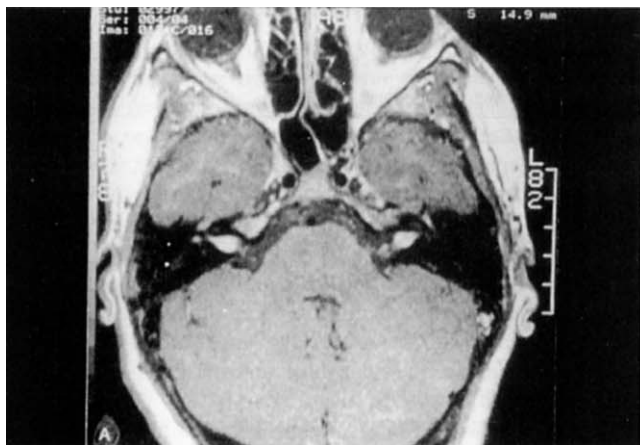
T-1 weighted, gadolinium-enhanced magnetic resonance image showing bilateral vestibular schwannomas without other intracranial tumors.
